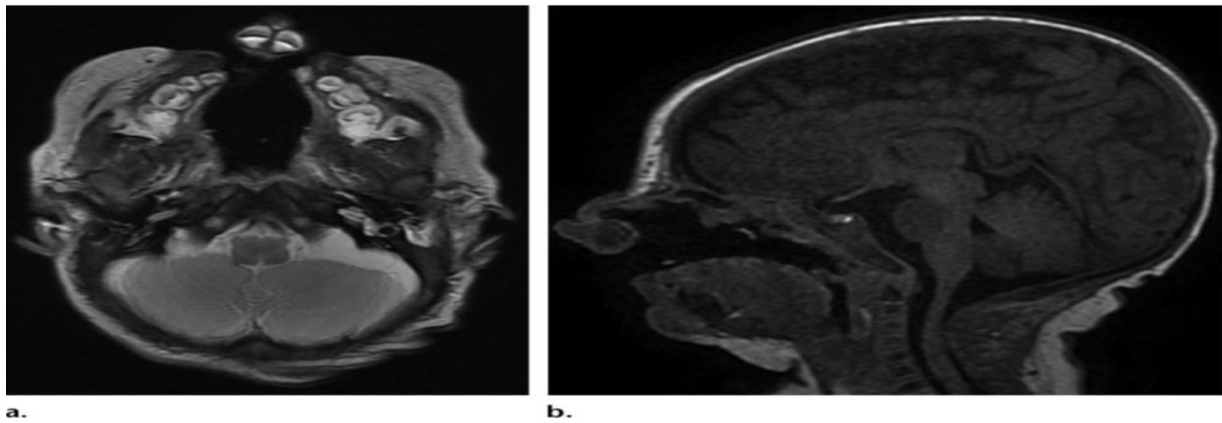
MR images in a 3-week-old boy show bilateral complete cleft lip and palate with a protrusive premaxillary segment. (Zachary2015).
